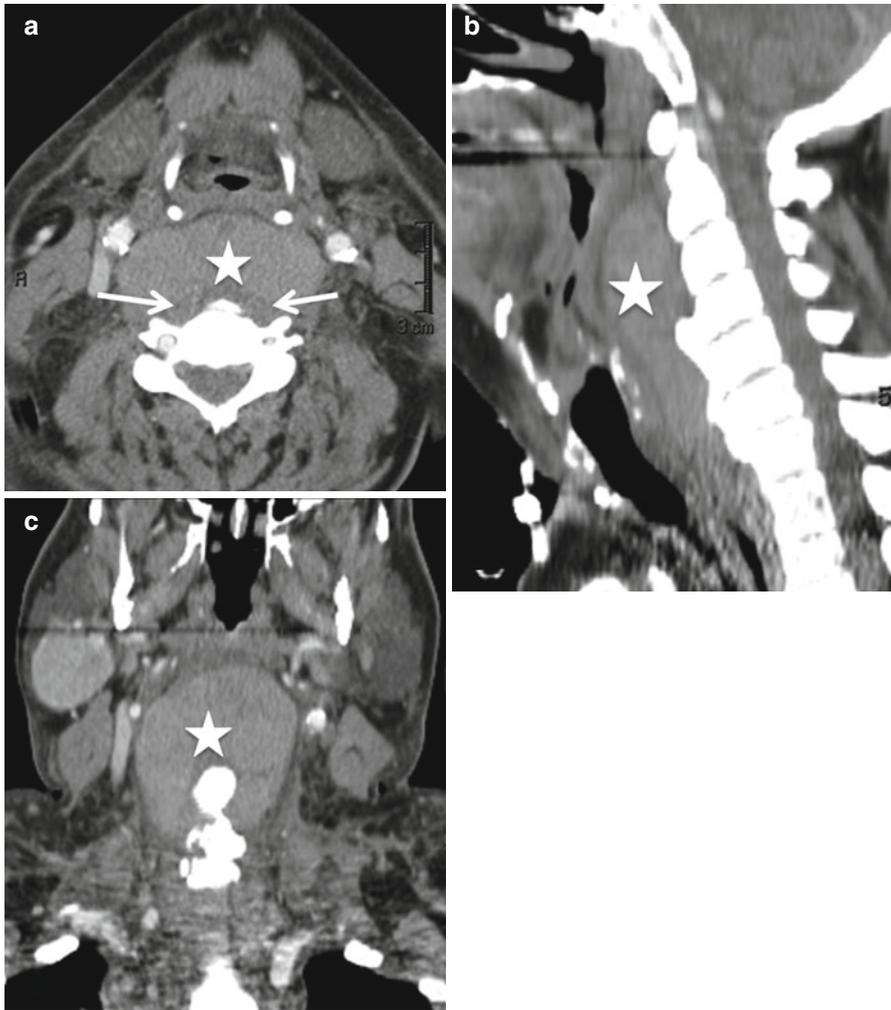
Retropharyngeal lymphadenopathy. Bulky non-necrotic retropharyngeal lymphadenopathy (*white star*) is seen in this patient with non-Hodgkin's lymphoma on the axial, sagittal, and coronal (a, b and c) contrast-enhanced CT images. Note the location of the prevertebral muscles, immediately posterior to the nodal mass (*white arrows* in a)
